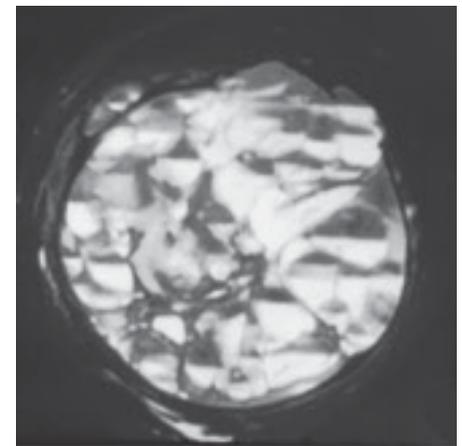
Aneurysmal bone cyst. MRI of large destructive lesion of distal femur. Note numerous fluid-fluid levels.
